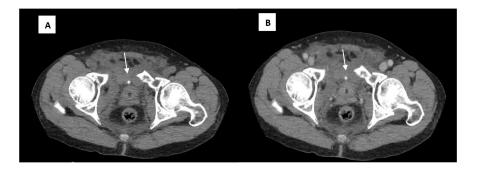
Bony fragment (white arrow) in a case of fracture pelvic bone, mimicking pseudoaneurysm in contrast-enhanced CT. However, the case was also interpreted as bony fragment in CECT alone, but with a less confident score.
